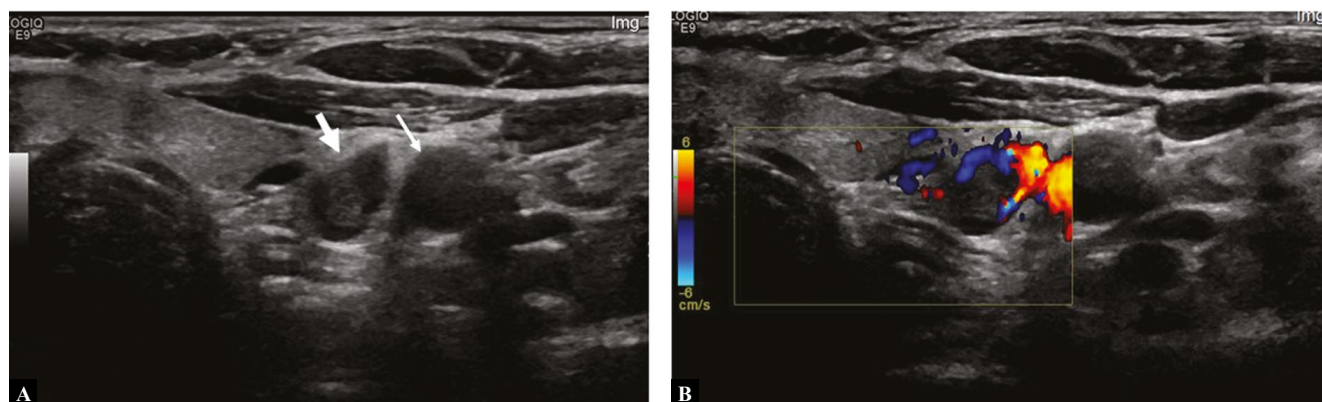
Axial B-mode (A) and Doppler (B) images of the lower neck showing a parathyroid adenoma (thick arrow) without internal vascularity and a vessel at the periphery of the lesion. Note the left CCA (thin arrow) in the vicinity of the lesion
